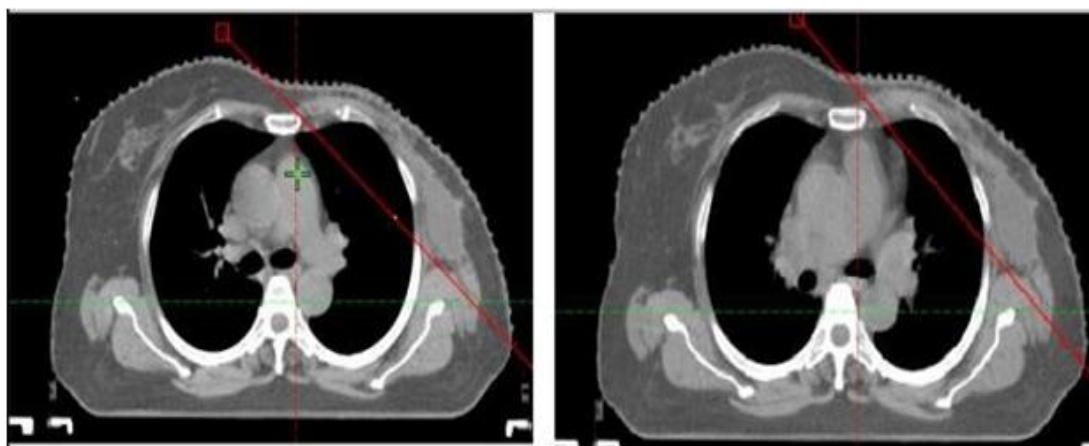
Axial section of CT thorax showing the effect of breath hold
